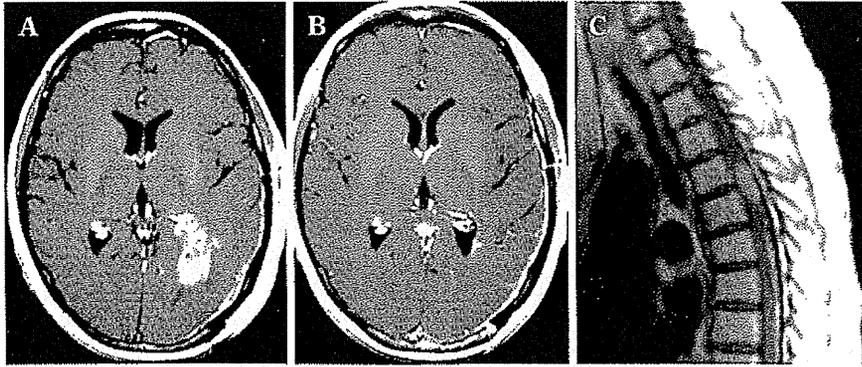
Periodic Gd-enhanced MRI findings of a GBM case treated by BNCT. A newly diagnosed GBM case in which the left trigonal lesion was treated by BNCT. A: Brain MRI, prior to BNCT. B: Brain MRI, 8 months after BNCT. C: Spinal MRI, 8 months after BNCT, showing CSF dissemination of the lesion at the spinal cord.
